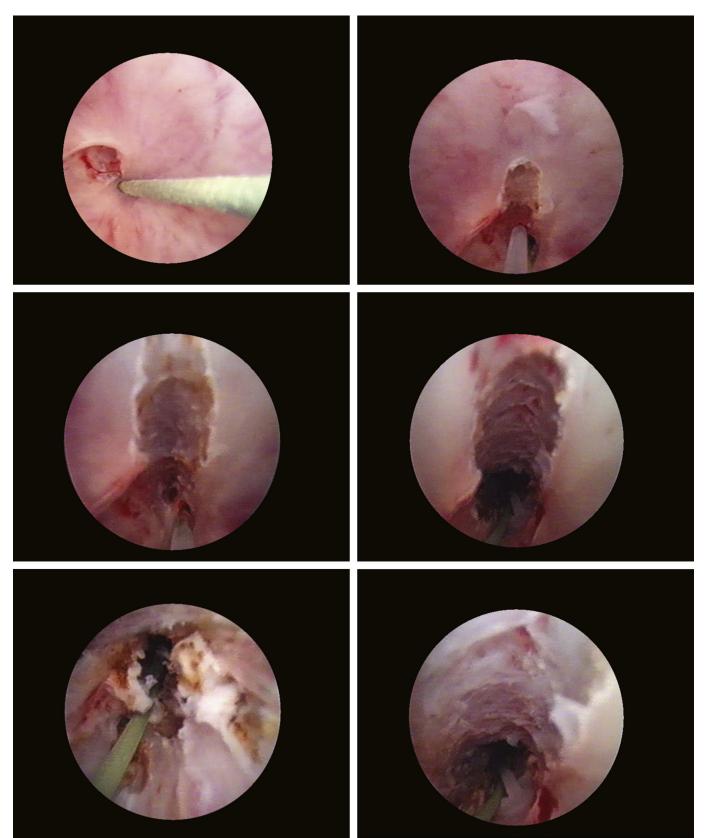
Laser incisions performed at 6 and 12 o'clock, according to ultrasound examination.
